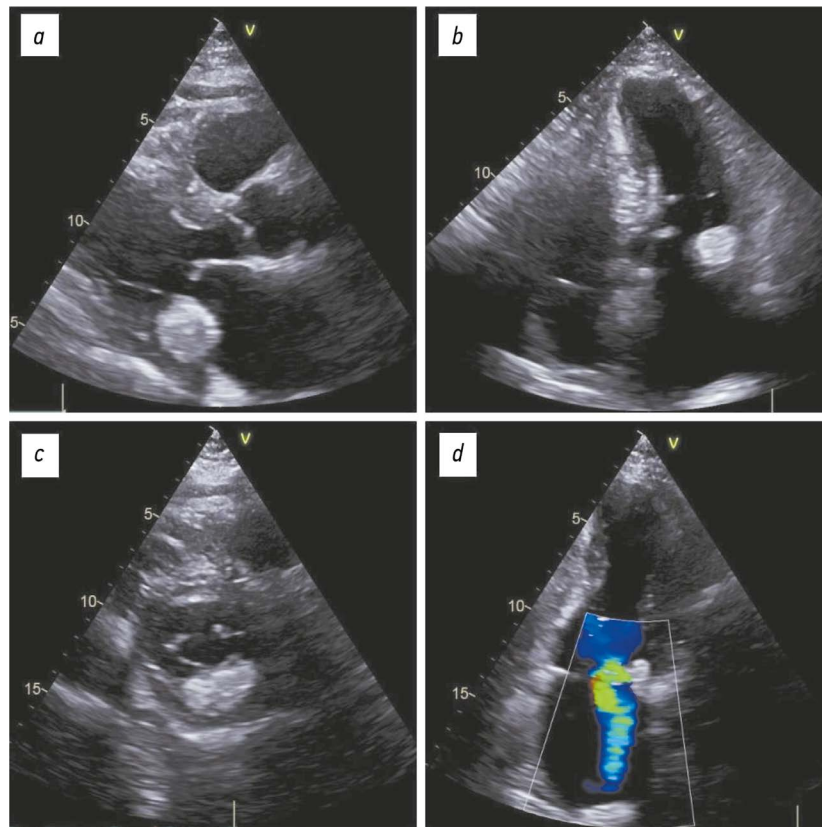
Transthoracic echocardiography, B-mode, clinical case 1: *a–c*, mass located near the posterior mitral leaflet; *d*, evidence of mitral regurgitation on Doppler ultrasonography; *a*, parasternal long-axis view; *b*, apical four-chamber view; *c*, parasternal short-axis view at the mitral valve level; *d*, apical two-chamber view.
